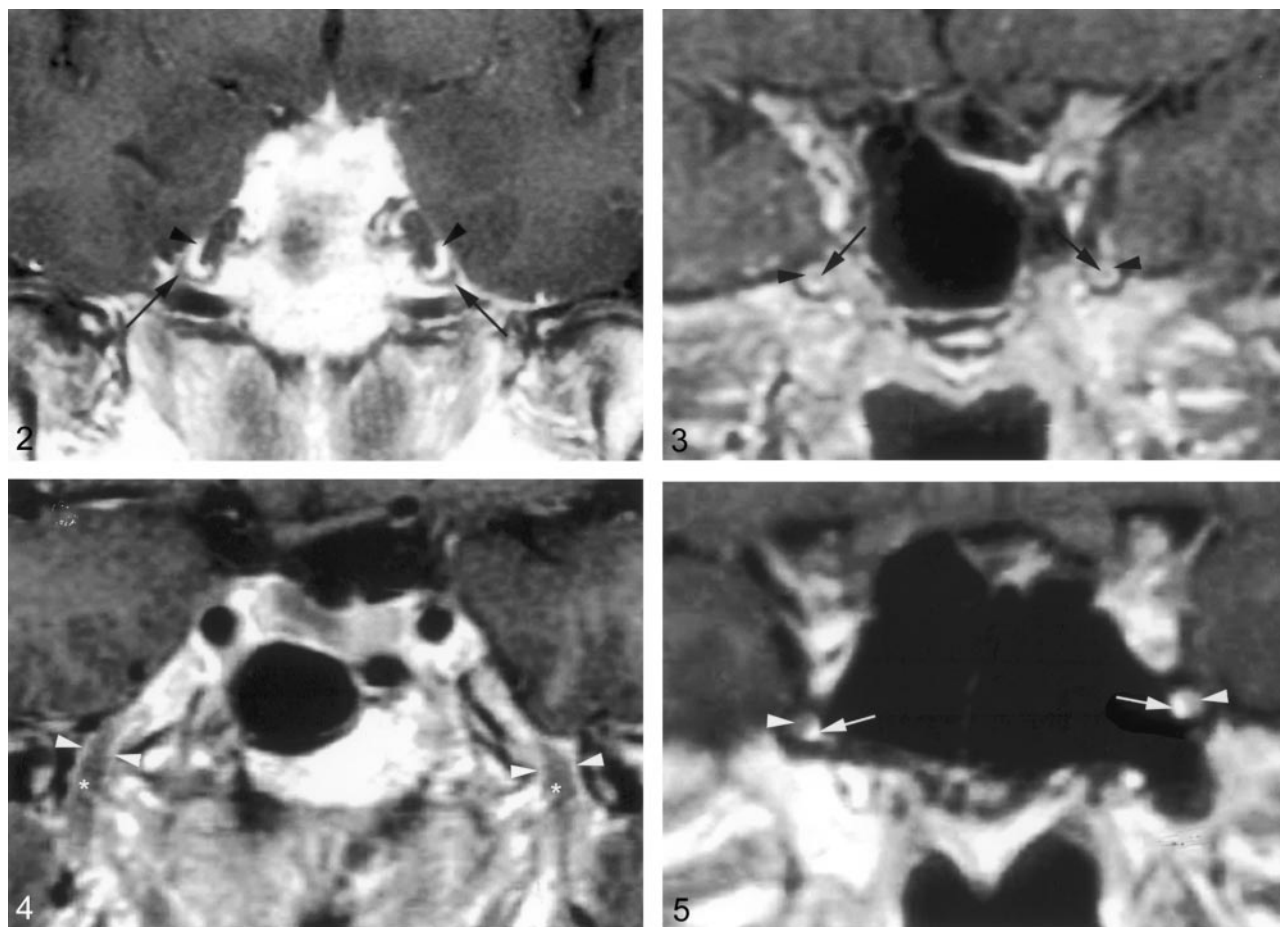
Coronal gadolinium-enhanced T1-weighted image (TR/TE/NEX, 400/15/2) depicts the nonenhancing crescent-shaped trigeminal ganglion (arrows) and the prominent perineural venous plexus (arrowheads) superior to it. The venous plexus as well as the ganglion are symmetric in appearance.
